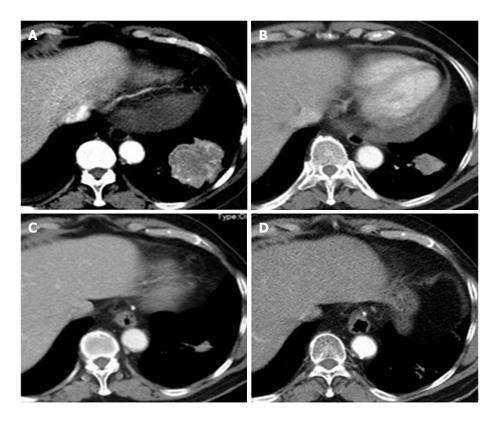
Transverse computed tomography scan findings of patients before and during treatment. A: Pre-treatment transverse computed tomography (CT) scan showing the tumor mass in the basal segment of the left lower lobe. The greatest dimension of the tumor measured 5.7 cm; B: One month after treatment, transverse CT scan showed significant reduction in tumor size. The greatest dimension measured 3.5 cm; C: Seven months after treatment, CT scan showed further significant reduction in tumor size. Greatest dimension was reduced to 1.8 cm; D: CT scan 45 mo after treatment showed that tumor almost disappeared (only fiber scar tissue was found by puncture biopsy).
